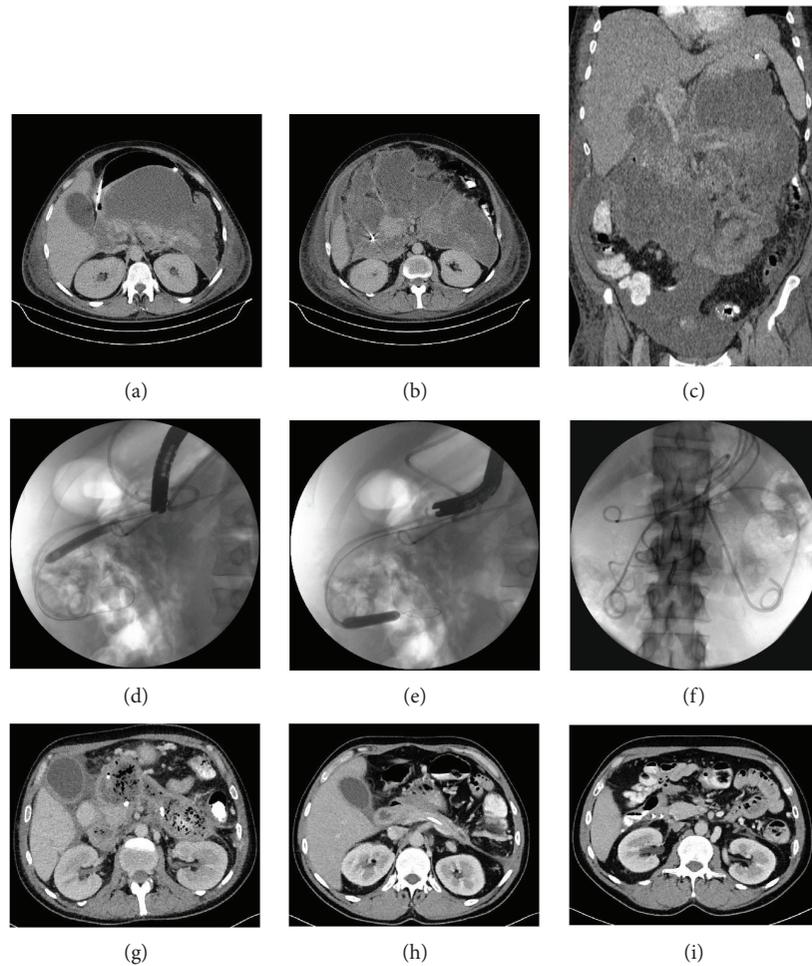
The patient with an extensive walled-off pancreatic necrosis visible in contrast-enhanced computed tomography (a, b, c). SGTMD technique was exploited for treatment (d, e, f, g). CECT performed after the end of endoscopic treatment stated complete regression of WOPN (h, i).
